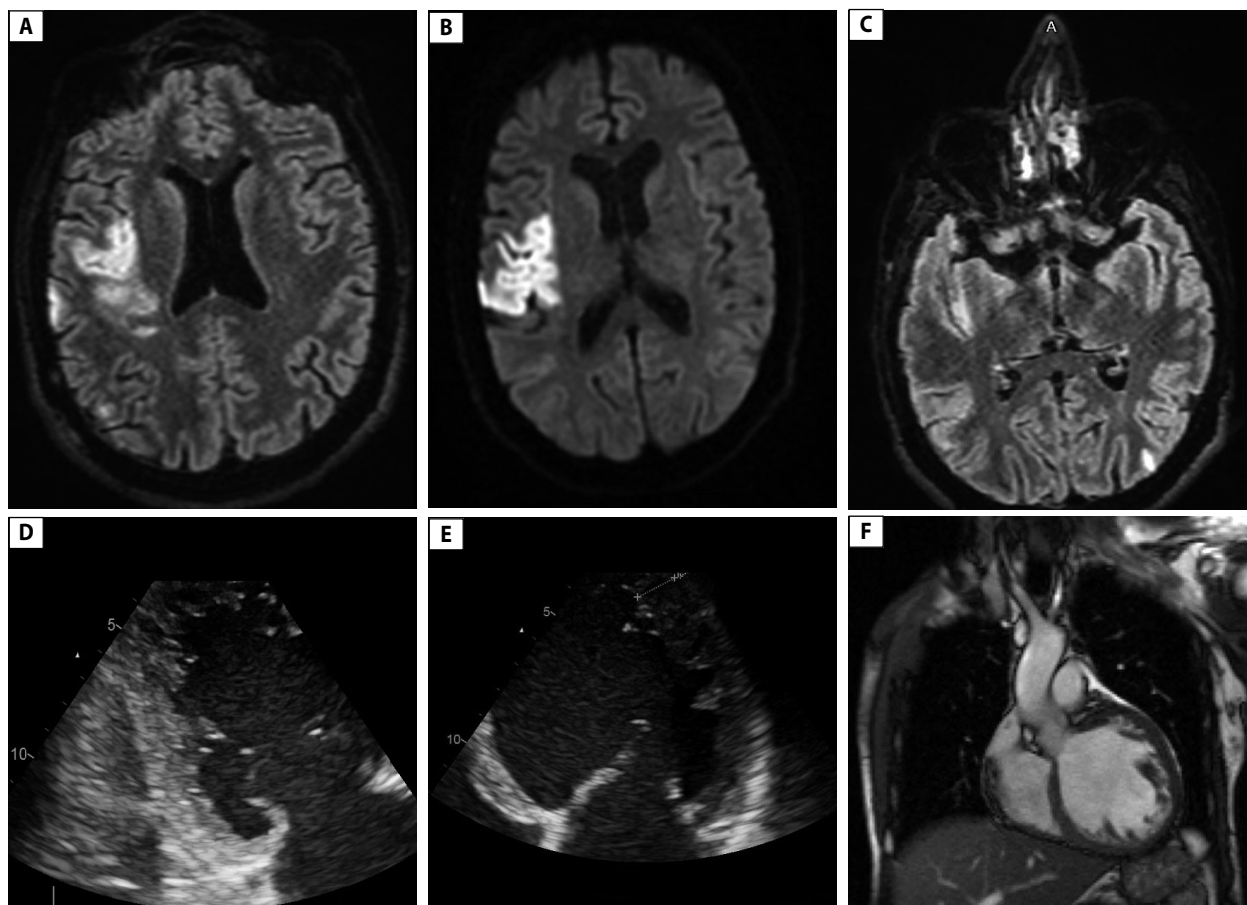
A. axial FLAIR: high signal in right MCA territory; B. Axial diffusion: confirming acute right superficial MCA ischaemic stroke; C. Axial FLAIR: small left parietal area with high signal; D. Echocardiography: apical two-chamber view: > 3 prominent trabeculations with deep intertrabecular recesses (Stöllberger criterion) [5]; E. Apical four-chamber view, end-diastole, left ventricle zoom, 2-layered myocardium with non-compaction/compaction ratio = 1.3 cm/0.7 cm = 1.85 (Paterick criterion: ratio > 2) [6]; F. Cardiac MRI: myocardial non-compaction of left ventricle
